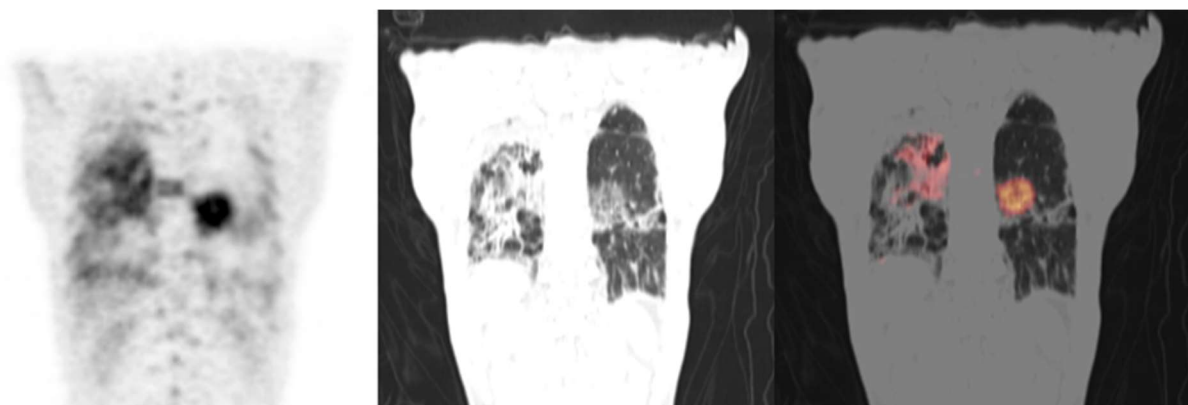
Tuberculosis reactivation caused by chemotherapy-induced immunosuppression. A 47-year-old male developed new-onset fever, cough and dyspnoea while undergoing chemotherapy for Hodgkin lymphoma. FDG PET/CT scan was obtained as part of his work-up. Images show FDG-avid lesions in the lungs bilaterally. Diffusely increased bone marrow FDG uptake is seen consistent with bone marrow reactivation caused by anaemia induced by chemotherapy. Pulmonary tuberculosis was confirmed as the cause of the lung lesions following a positive sputum culture for *Mycobacterium tuberculosis*. This case highlights the role of immunosuppression induced by cancer chemotherapy in the reactivation of latent tuberculous infection.
